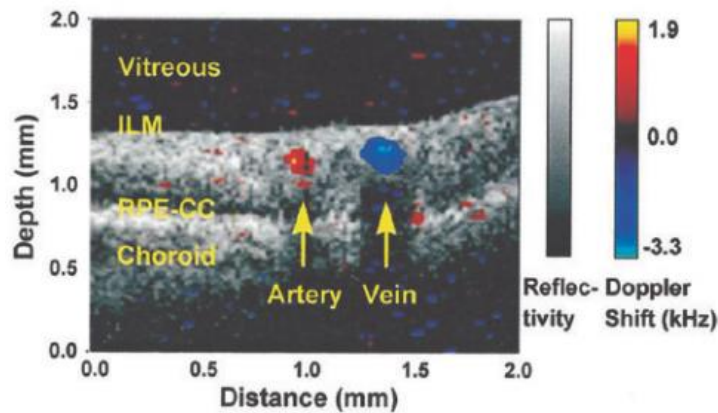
Doppler OCT images of bidirectional blood flow in retina. Reprinted from Yazdanfar et al (2000) with permission.
